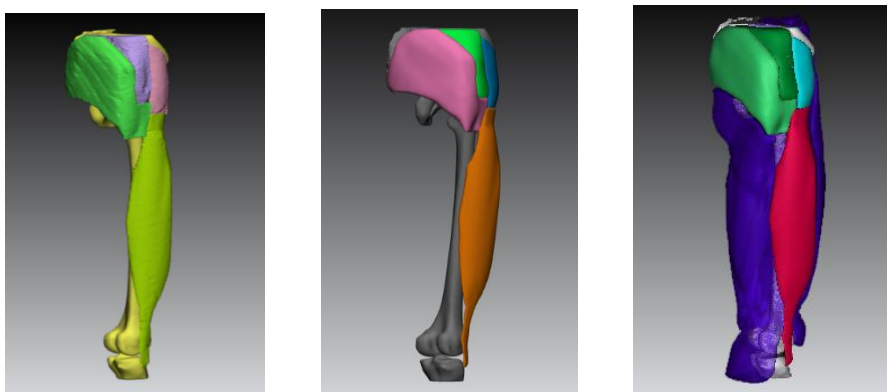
Three views of anatomical plane in CT image
